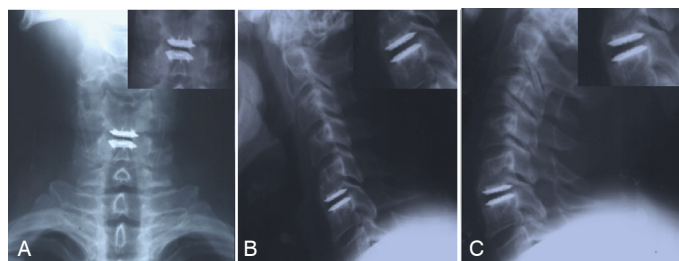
A 41-year-old male patient with C5-C6 intervertebral disk degenerative disease treated by CDA. Clear signs of HO grade III can be seen, with no significant reduction in motion of the prosthesis on flexion and extension at 5-year follow-up: A – frontal radiography, B – lateral radiography with flexion, C – lateral radiography with extension.
